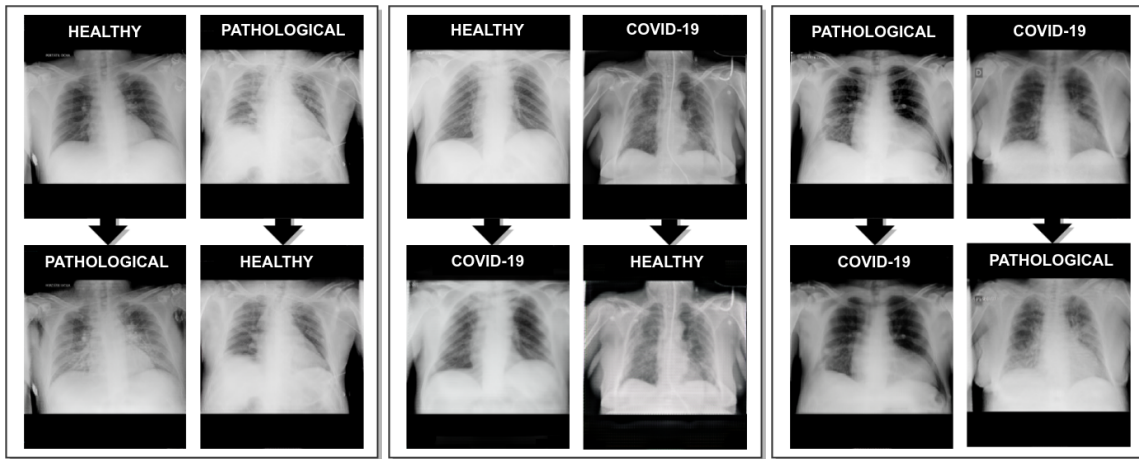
Examples of generated chest X-ray images from the complete oversampling methodology. 1st block, healthy vs Pathological scenario. 2nd block, Healthy vs COVID-19 scenario. 3rd Pathological vs COVID-19 scenario.
